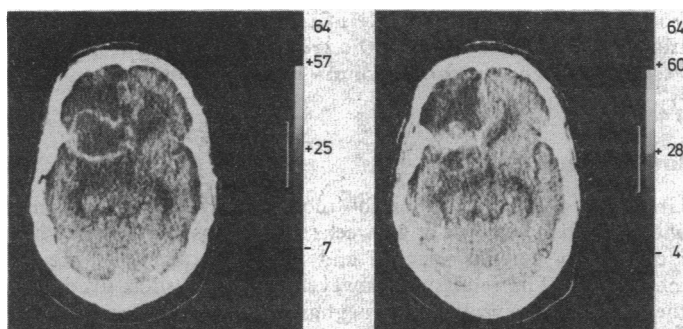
Computed tomograms taken at the same level (left) before antibody guided treatment, showing area of tumour and surrounding oedema, and (right) four months after antibody guided treatment, showing area of tumour. Note reduction in size of tumour but persistence of cerebral oedema.
